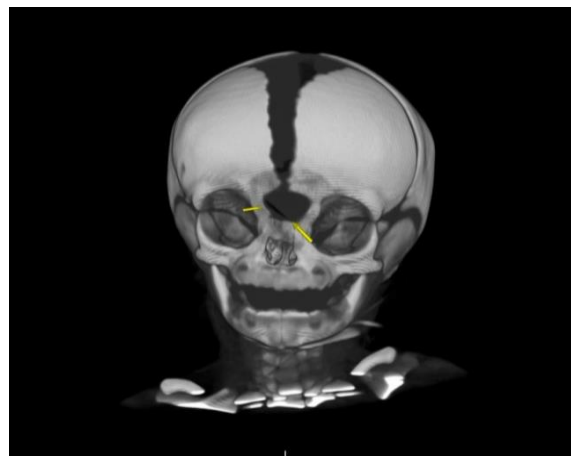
3-D reformatted computed tomographic image revealed a rounded nasoethmoidal osseous defect
